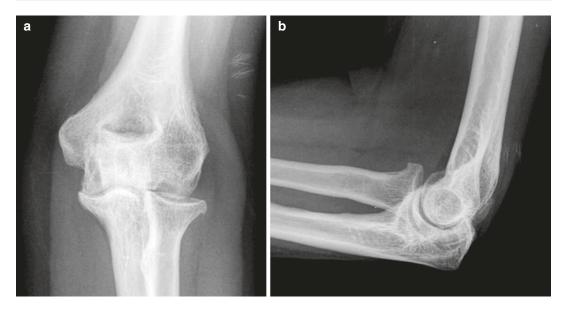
(a) Anteroposterior and (b) lateral plain radiographs of the same patient, showing thinning of the radiocapitellar joint space, osteophytes of the radial head and bone cysts in the capitellum (Courtesy of MoRe Foundation)
